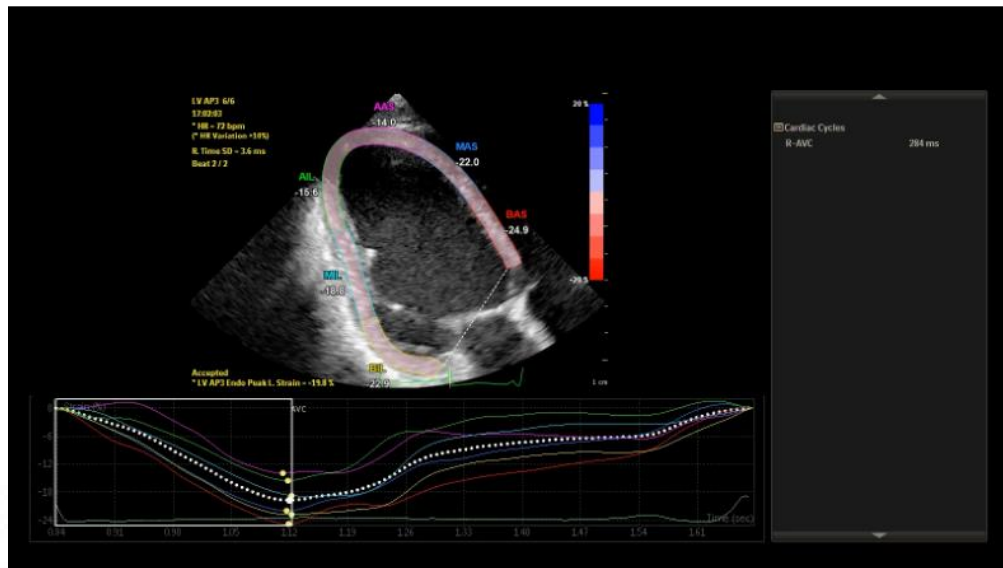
12: Regional 2D images in apical 4,3,2 chamber views reconstruct the entire 18 segment myocardial model*
